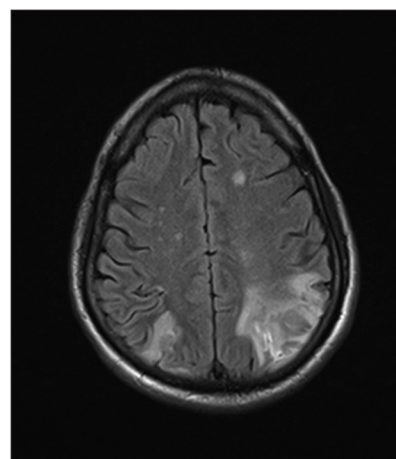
Magnetic resonance imaging - bilateral parietal infarcts
